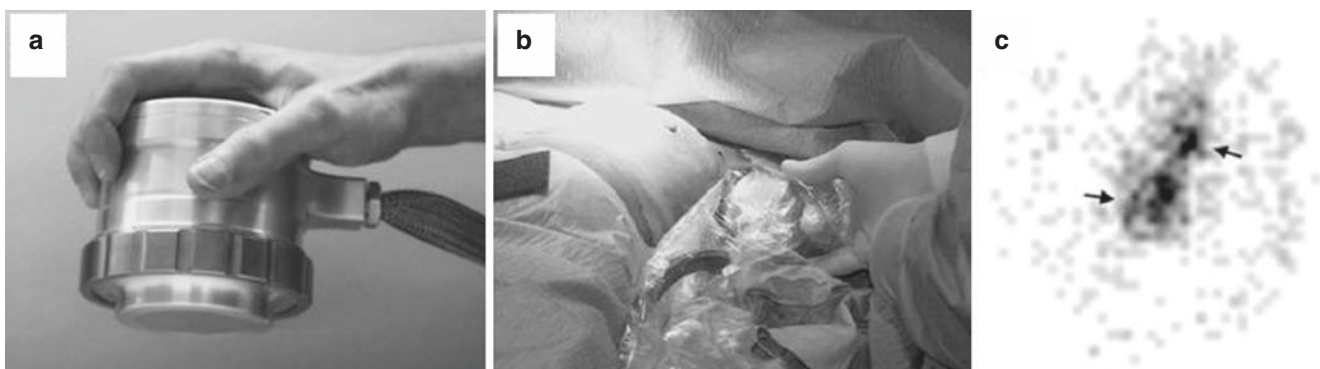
(a) Photograph of the POCI (Per-operative Compact Imager) intraoperative gamma camera. (b) Intraoperative lymphoscintigraphy, with the POCI in position for imaging of the patient’s left axilla. (c) POCI image (10-s acquisition time), showing two foci of activity corresponding
